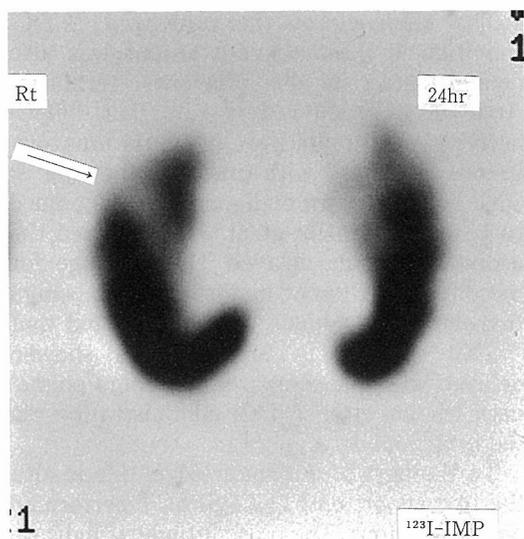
^{123}I -IMP SPECT obtained 24 hr after the injection showed defective uptake within the lesion.
